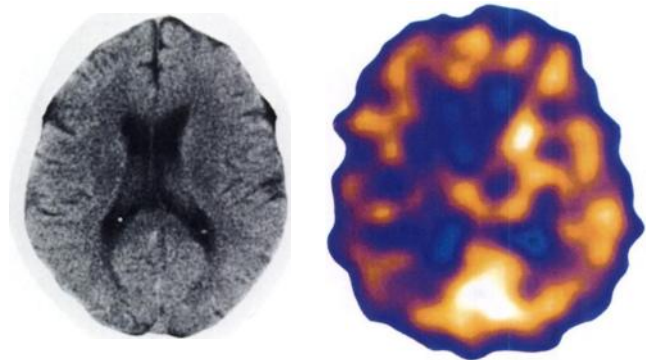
Despite a normal CT study upon admission (left), this patient with left-sided weakness demonstrated decreased right hemisphere uptake in a SPECT study (right) performed with SPECTamine.
